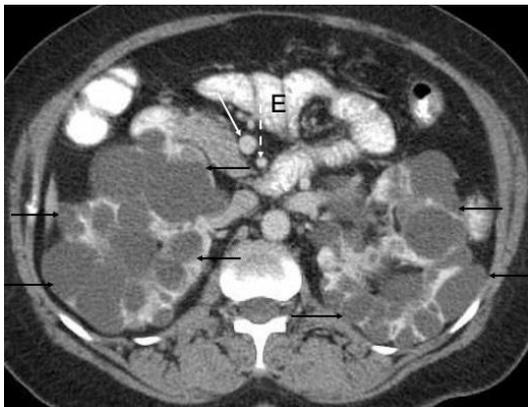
A contrast-enhanced CT abdomen of a 45-year-old female with autosomal dominant polycystic kidney disease shows multiple non-enhancing low-density lesions (solid black arrows) in both kidneys. The patient was given oral contrast as evident by the hyperdense small bowel loops (E). Solid and dashed white arrows point to the SMV and SMA, respectively
